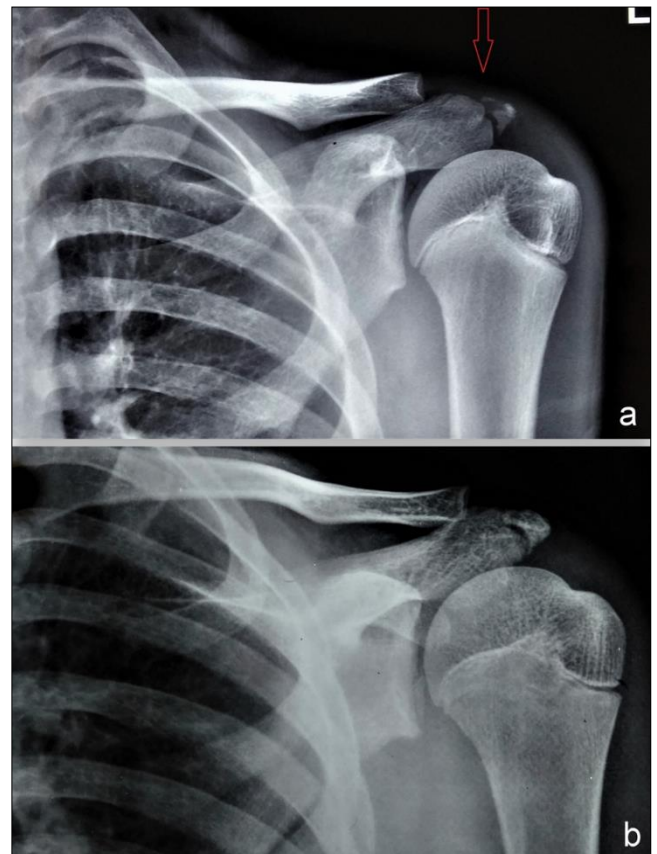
The radiograph of the shoulder showing increased distance between acromion apophysis and the scapula spine along with irregularity between surfaces(a) and the healing of the disorder and union with native bone in the follow up (b).
